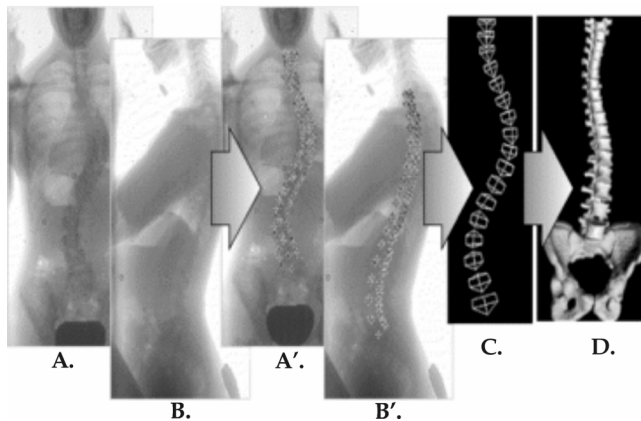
"Standard" main steps of 3D modelling process of the vertebral structures: (A. B.) radiographic orthogonal AP (A.) and lateral (B.) views (A'. B'.) manual identification of six anatomical landmarks per vertebra, (C.) "standard" 3D reconstruction of the anatomical landmarks, (D.) visualization of the geometric model
